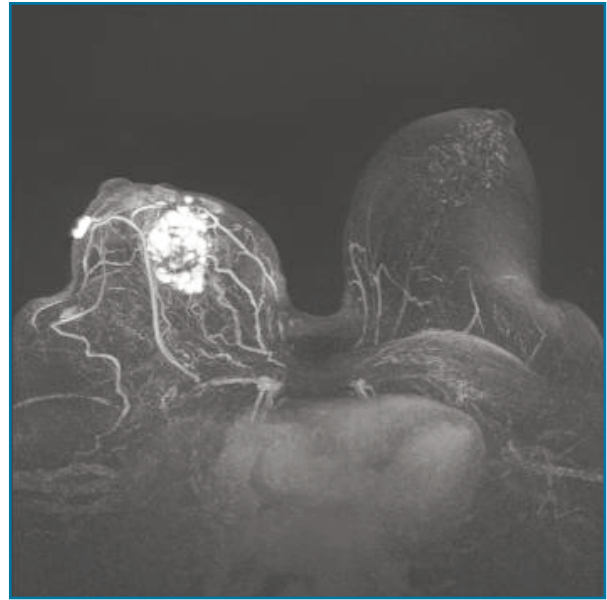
MRI showing a regular mass with 4,5 cm, involving the skin but not the underlying muscle of the right breast.
